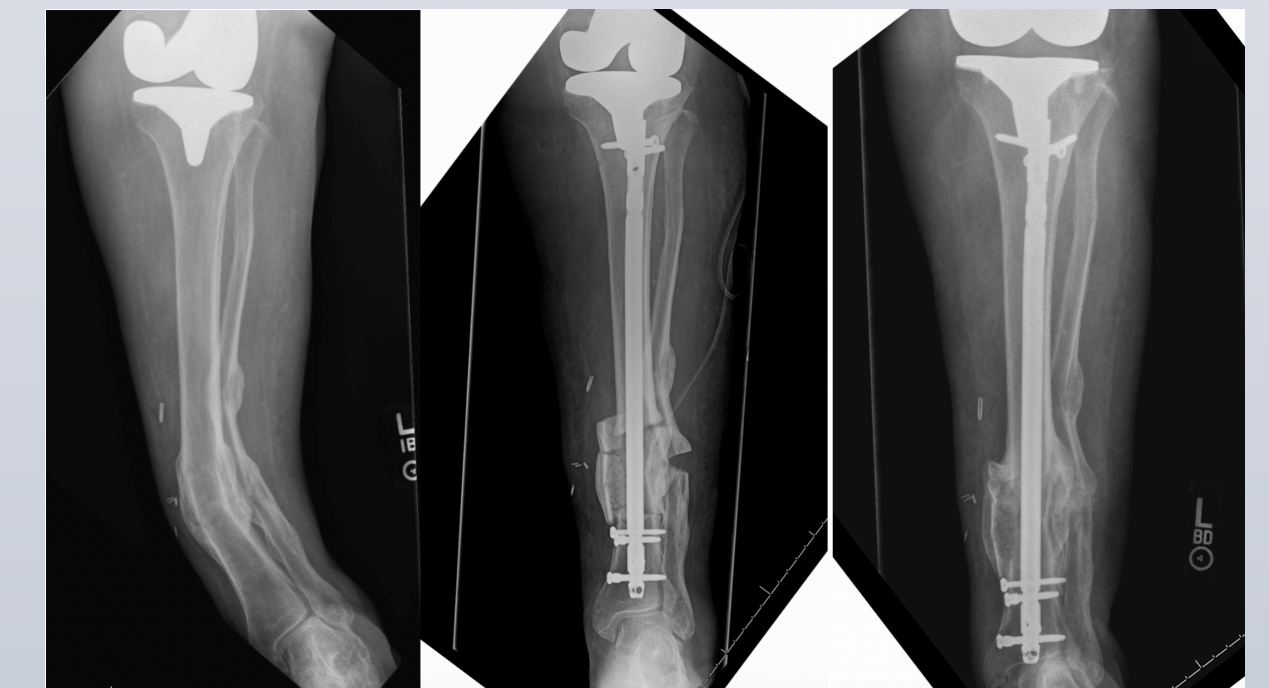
Preoperative (left), immediately postoperative (center) and healed (right) radiographs
